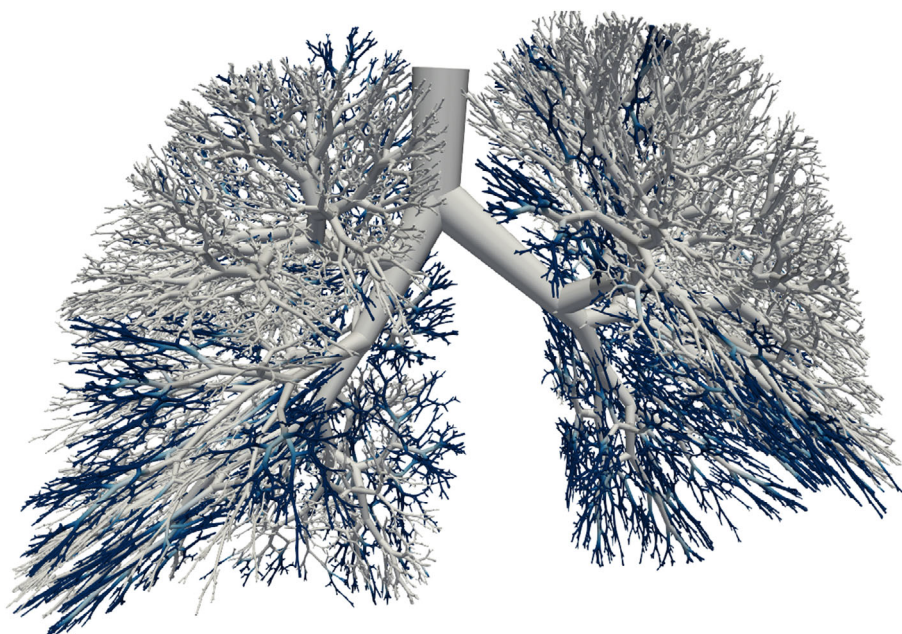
Generated airway tree with (de-)recruitable airways (black) identified by regions in CT scan with densities above -300 HU.
